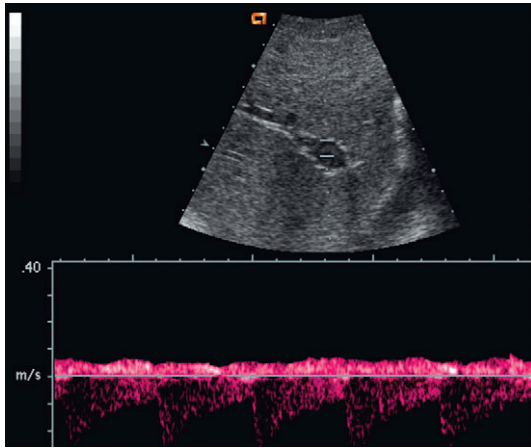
Spectral Doppler tracing over the portal vein in a patient with hepatocellular carcinoma (HCC). An arterial waveform is present in a plug of tissue identified extending into the portal vein. This represents HCC primarily perfused by arterial flow.
